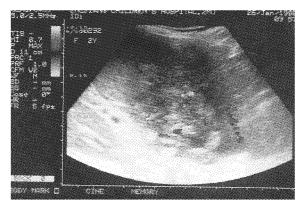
Wilms' tumor before treatment, the abundant blood stream shown by Doppler ultrasonography.
